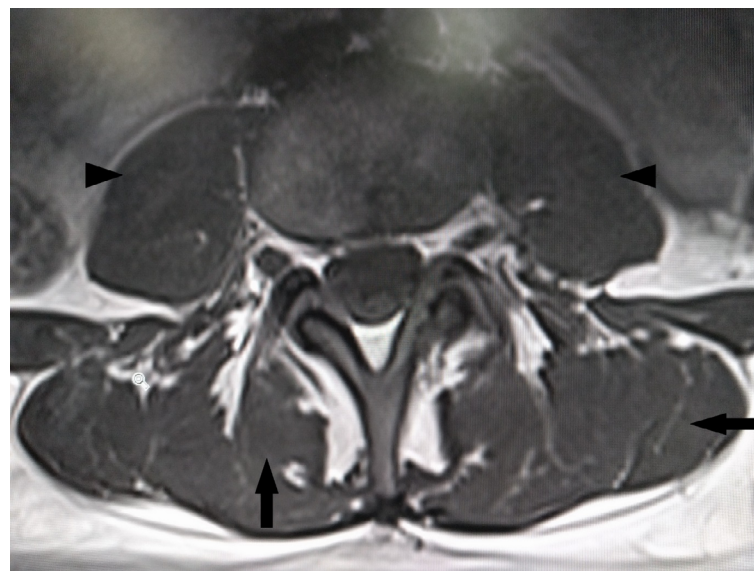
Axial MRI of the lumbar spine - T1 weighted image at the L4/5 level
